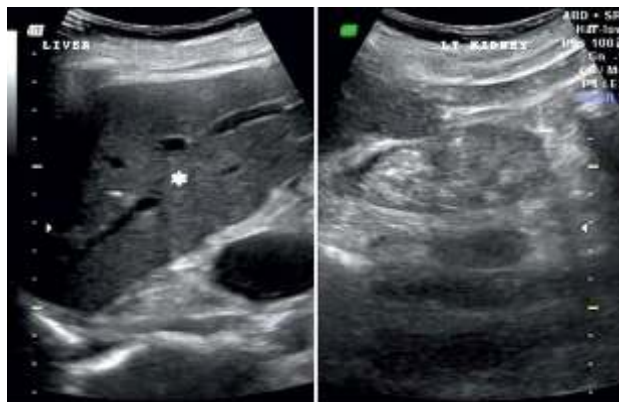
The longitudinal segment of the abdominal ultrasound reveals Grade 4 renal cortical echogenicity, which is characterized by more echogenicity than the liver (star) and a lack of cortico-medullary delineation (arrow) in the left kidney.
